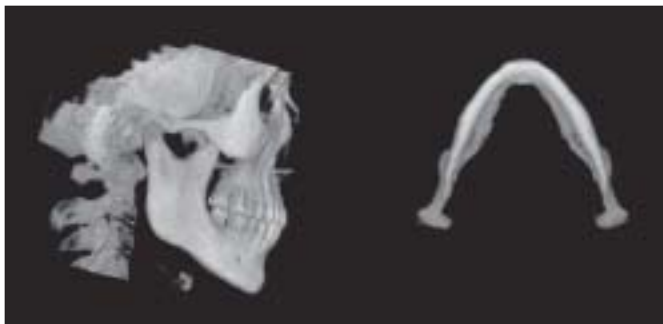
Three-dimensional rendering of the skull from cone-beam CT data. The lateral projection of the skull is shown on the left and a rendering of the mandible alone is shown from below, on the right.
